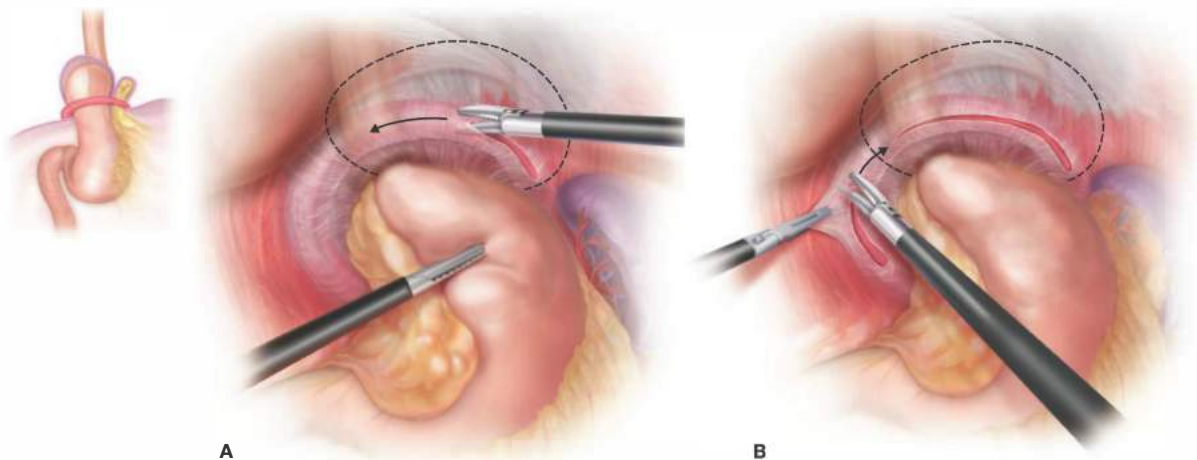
• A,B. Dissection from left to right, anteriorly, starting on the left crus. Ultrasonic dissection takes place directly on the edge of the diaphragm at all times. Countertraction must be kept to prevent retraction of the hernia sac into the mediastinum.
